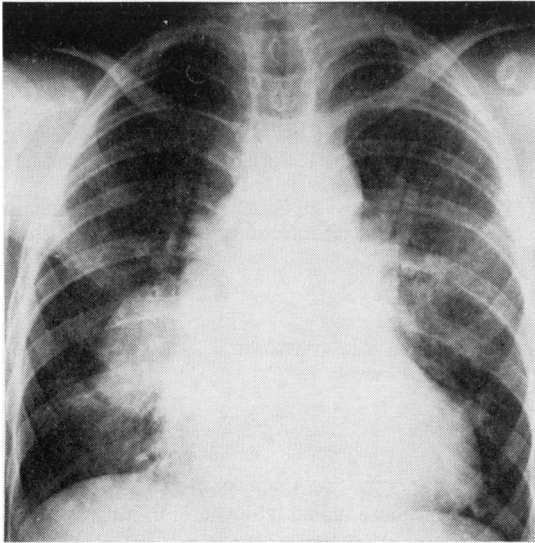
Figure Chest radiograph showing mass at right hilum.
